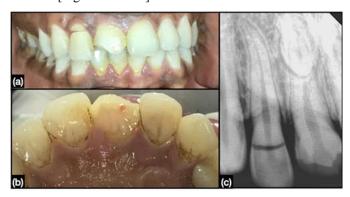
(a,b) Pre-operative photograph buccal and palatal view. (c) Preoperative radiograph.
